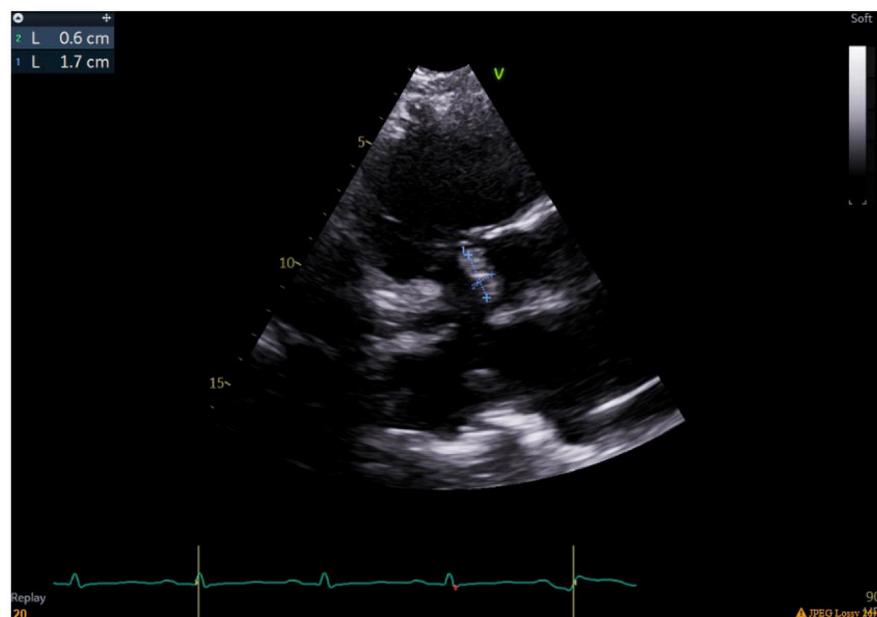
Transthoracic echocardiogram right ventricular inflow view of AICD lead vegetation.
